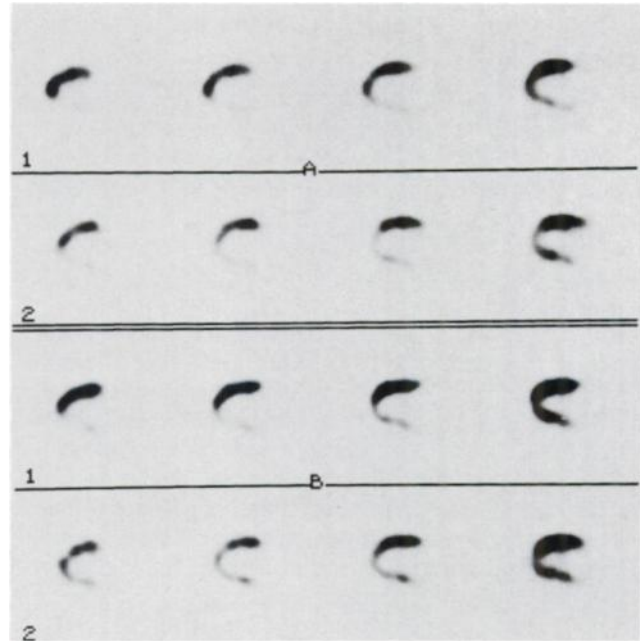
Example of a 73-yr-old male patient with coronary artery disease but without myocardial infarction (50% LAD, 50% LCx and 80% RCA stenoses). Protocol A: exercise SPECT images (A1) showed an inferior defect which was fixed on delayed imaging with reinjection alone (A2). Protocol B: exercise SPECT images (B1) also showed an inferior defect which completely normalized on delayed imaging with nitrates and reinjection (B2).
